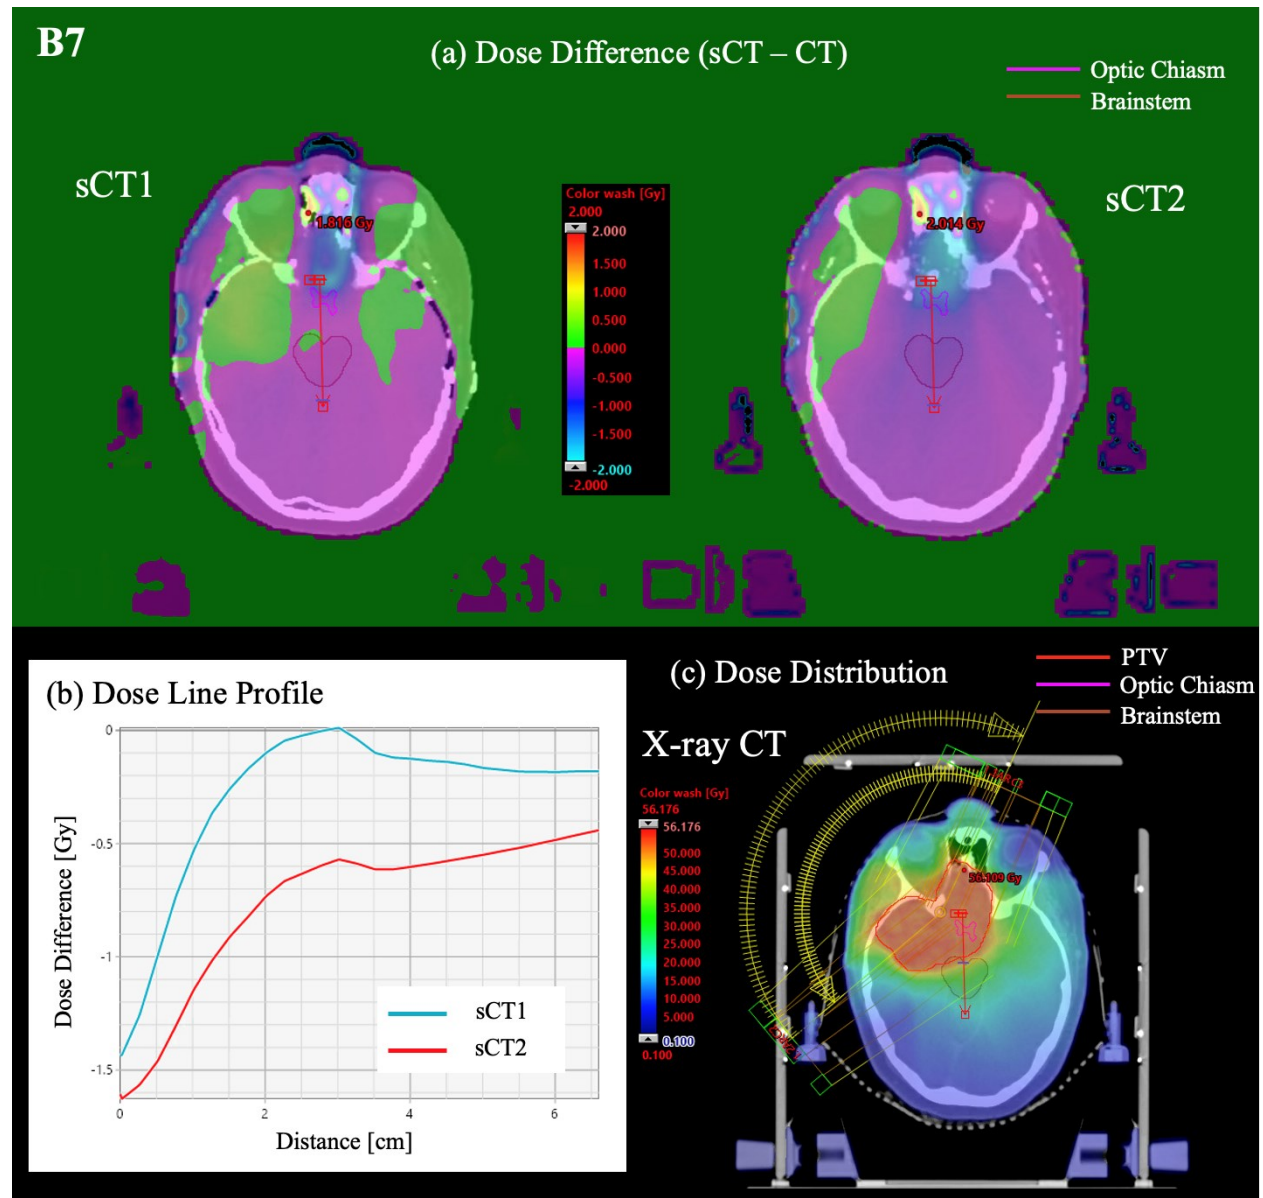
(a) Dose difference maps for sCT1 and sCT2, as compared to the dose distribution on X-ray CT, for patient B7. The PTV and some OARs including the brainstem and optic chiasm are contours to evaluate the dose distributions across these structures. (b) Dose line profile along a red line passing through the PTV, optic chiasm and brainstem on the sCT and X-ray CT images. (c) Dose distribution calculated on the planning CT image.
